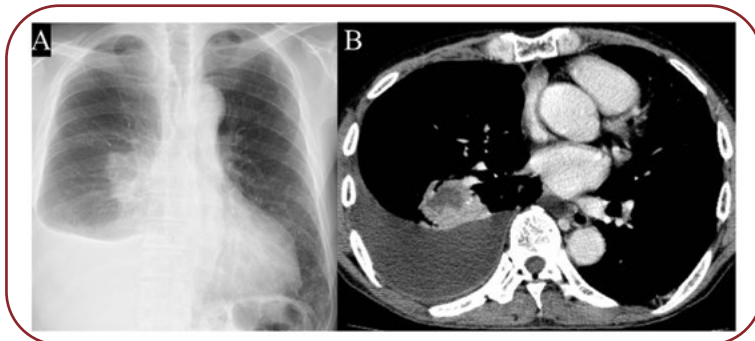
Chest radiograph (A) and computed tomography (B) taken at that time, which revealed massive right pleural fluid and a mass with low-density area in the lower lobe of the right lung
